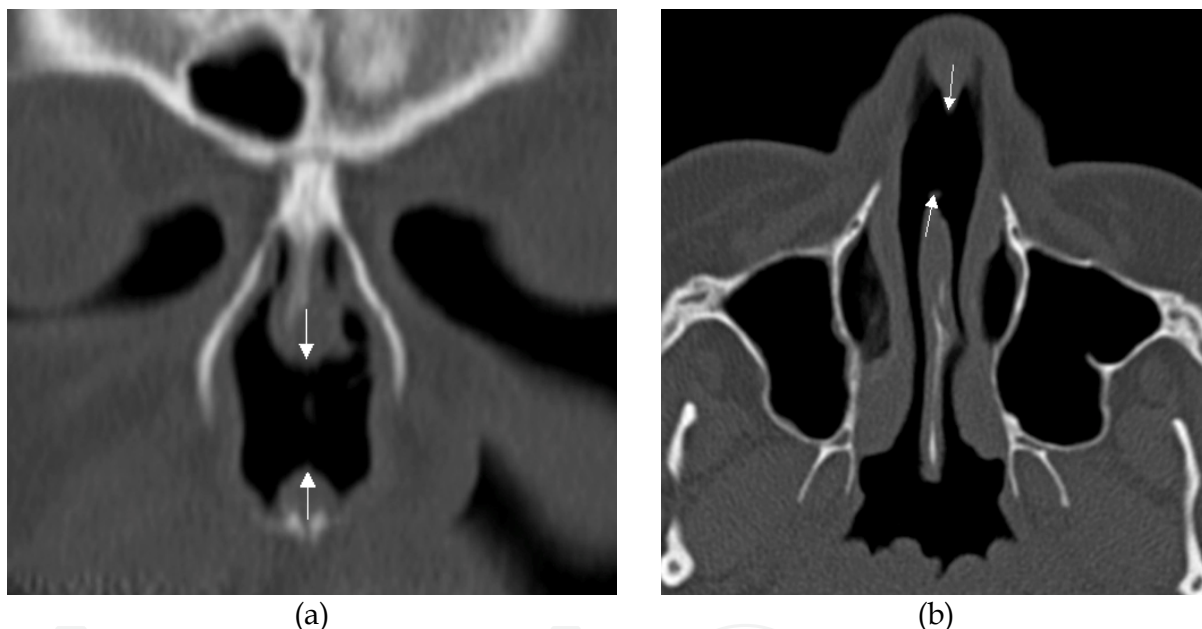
(a) Coronal and (b) axial CT shows a hole in the anterior nasal septum (arrows) in a patient abusing cocaine.
